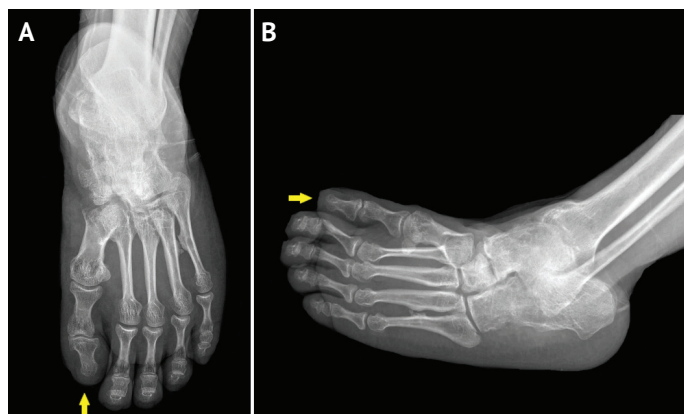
Anteroposterior (A) and lateral oblique (B) radiographs of the left foot, showing that the first metatarsal is shorter than others (yellow arrows).
